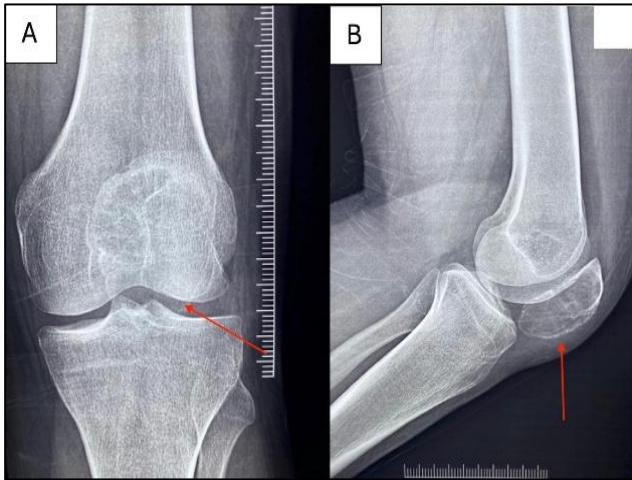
Preop radiographs obtained before COVID-19-related restrictions: (A) anteroposterior and (B) lateral views of well-defined lytic lesion confined to patella, with preserved cortical margins and no extension beyond inferior pole.
